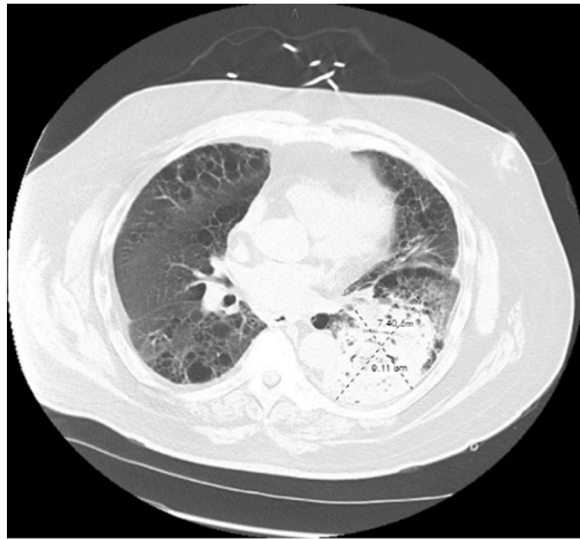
CT Chest significant for 12.6 cm mass in left lower lobe likely sequelae of recent microwave ablation vs developing infectious process.
